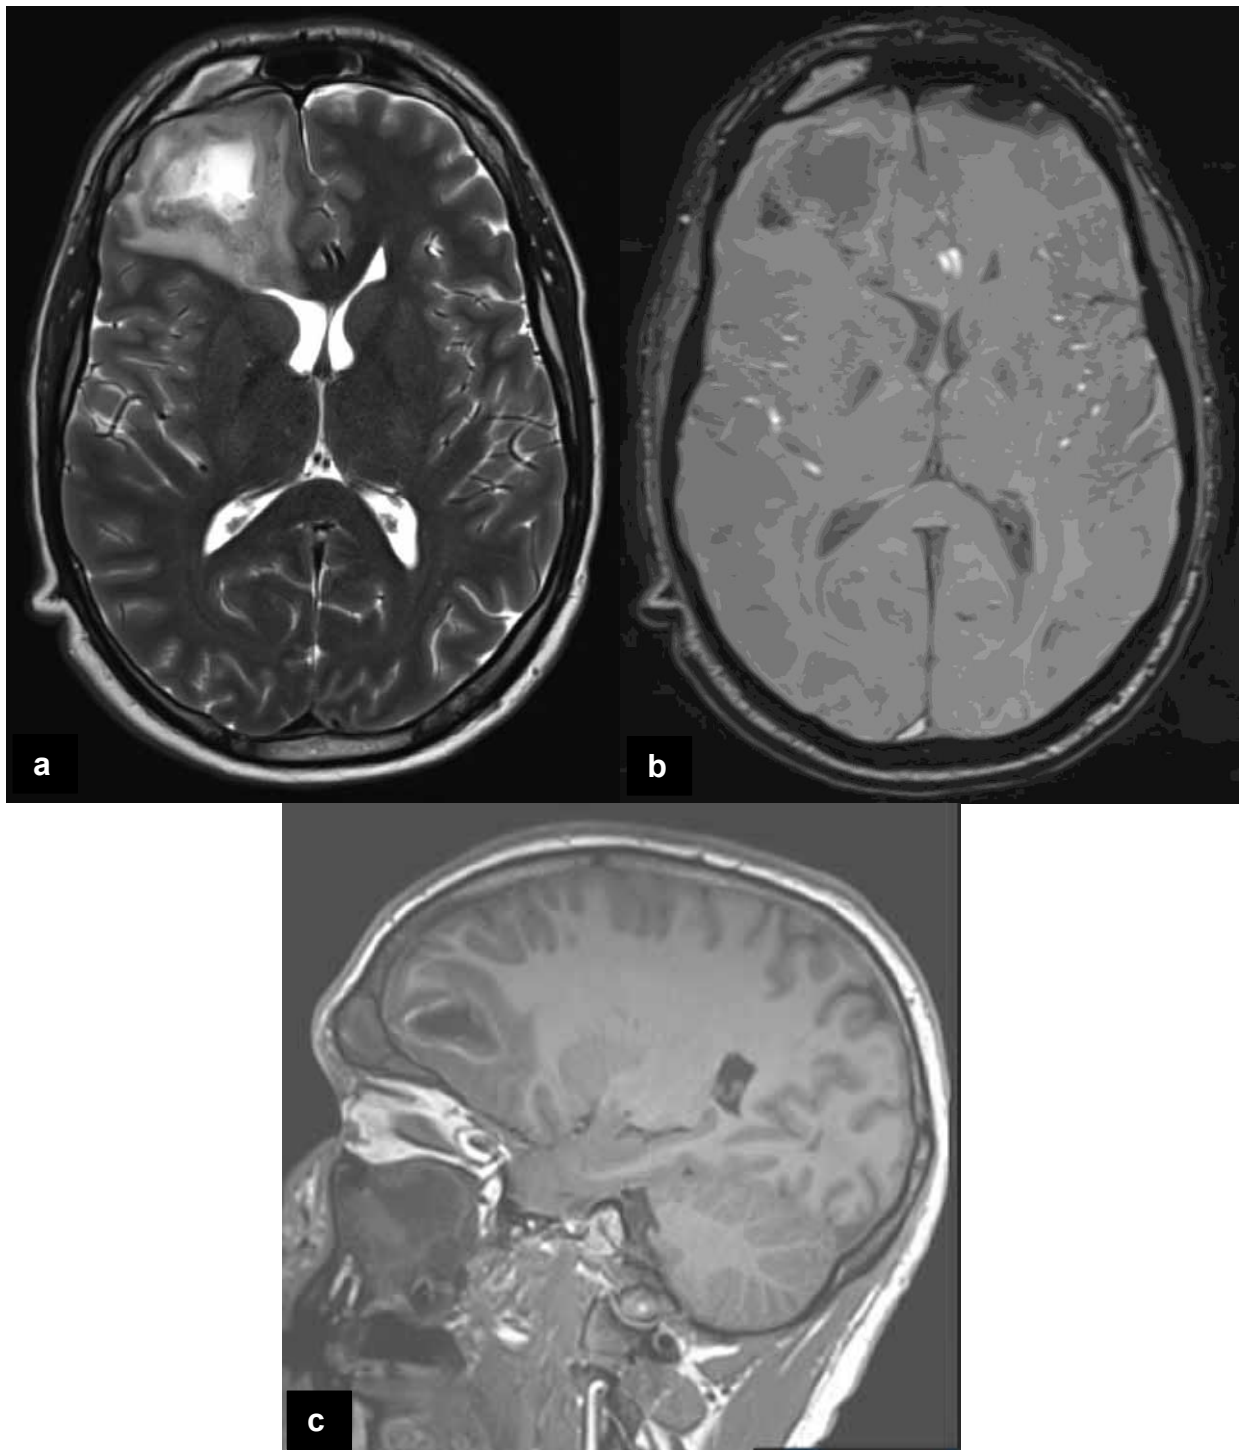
Brain MRI showing a very hyperintense lesion center on T2-weighted image, surrounded by an iso- to hypointense rim and a perifocal hyperintense edema (a), hypointense dots in the forming capsule on SWI sequence (b) and precontrast T1-weighted image rim hyperintensities (c), corresponding to a late cerebritis stage of a brain abscess. Frontal (a - c) and maxillary sinus (c) opacification. Right frontal ventricular horn compression (a, b).
